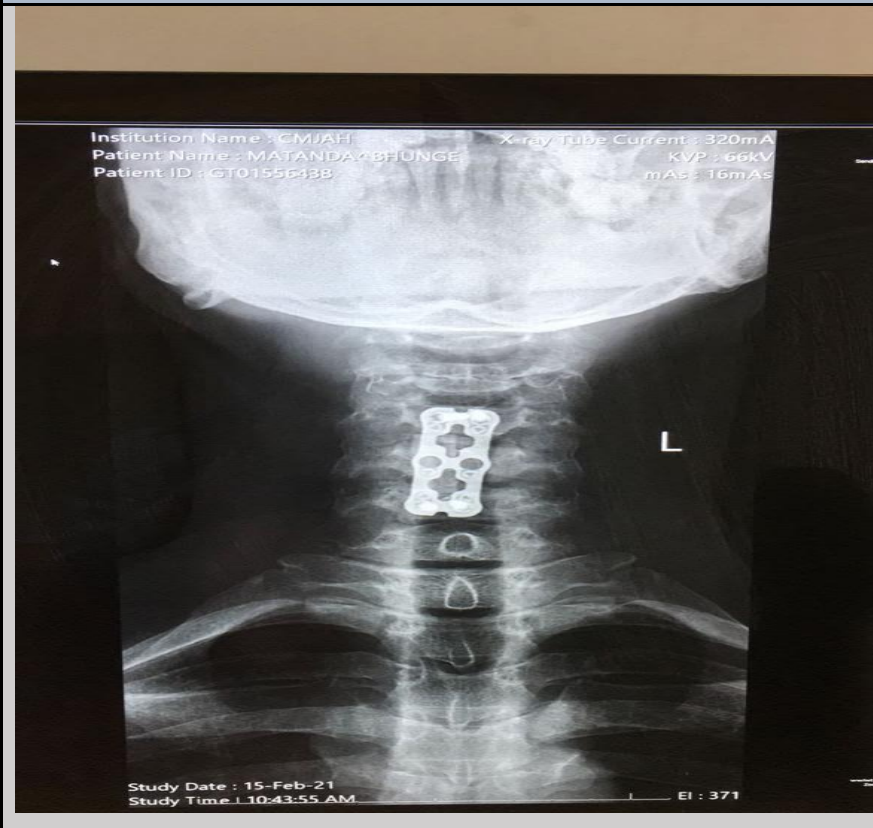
Radiographical follow up period assessed
